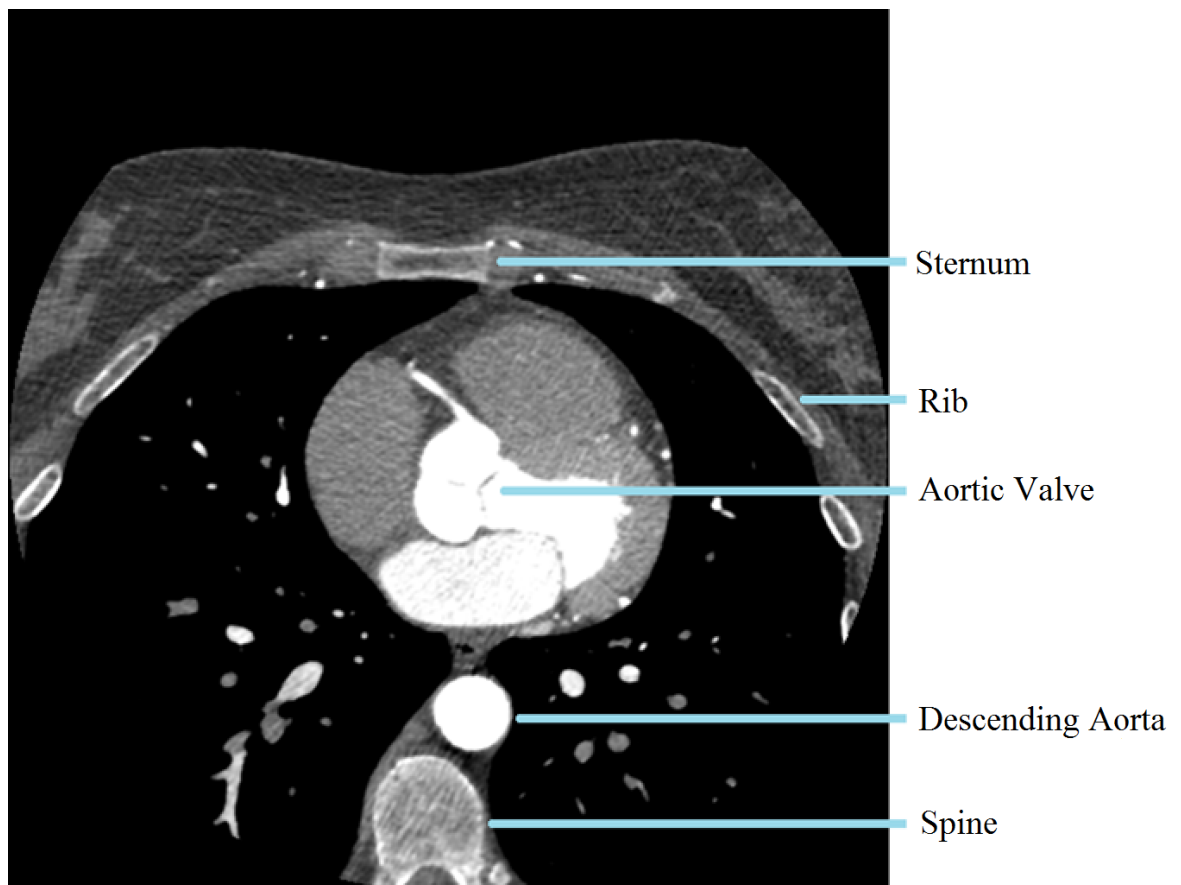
CT scan image revealing a cross section of the heart. The ribs, sternum, aortic valve, descending aorta and spine are all visible in the image. The dark areas with white islands on either side of the heart are the lungs.
